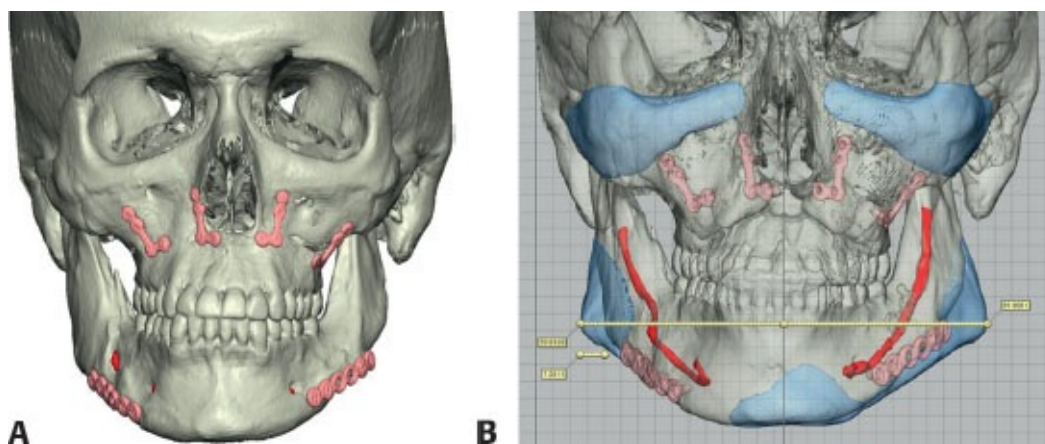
• A,B. Custom implants designed using CT scan data to correct irregularities and imbalance after
